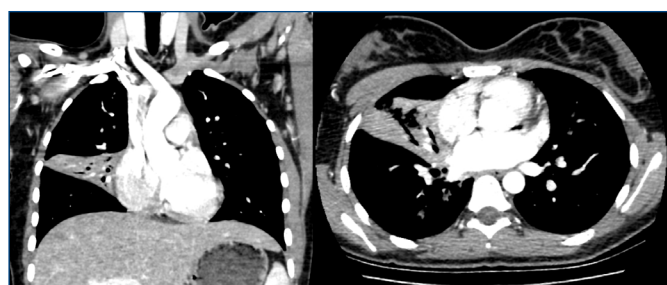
Hospital admission chest computed tomography
